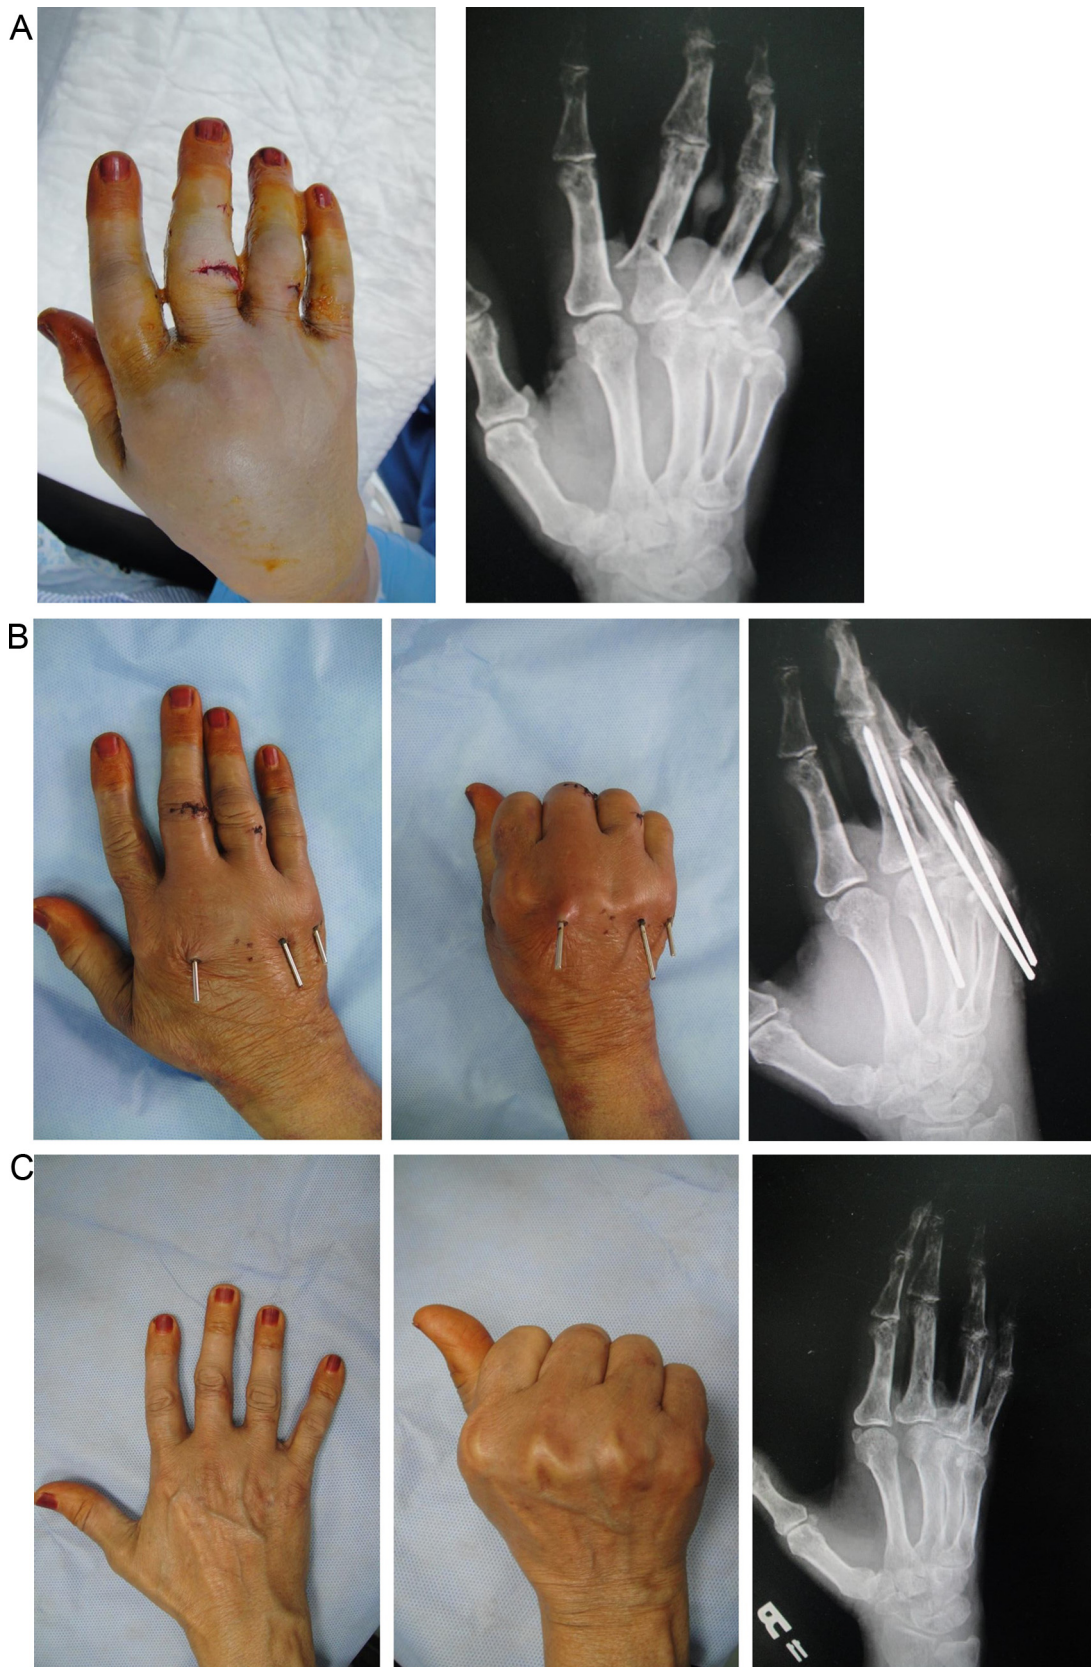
Case #1. A: Preoperative appearance and X-ray. B: Range of motion and X-ray at 10 days. C: Range of motion and X-ray at 3 months.
